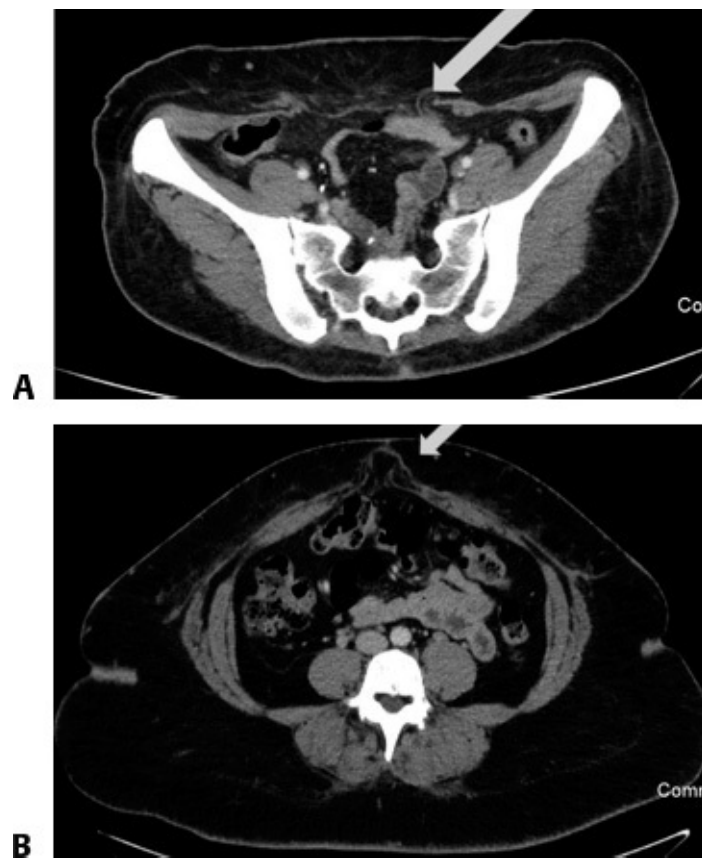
• CT scan can help delineate the extent of a hernia and can help with preoperative planning.
